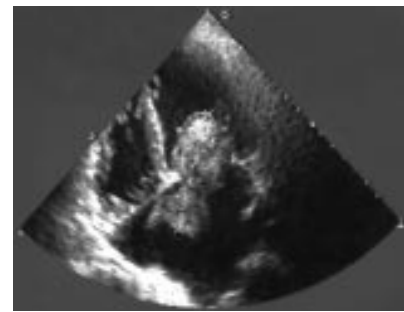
Transthoracic echocardiogram (four chamber view).
